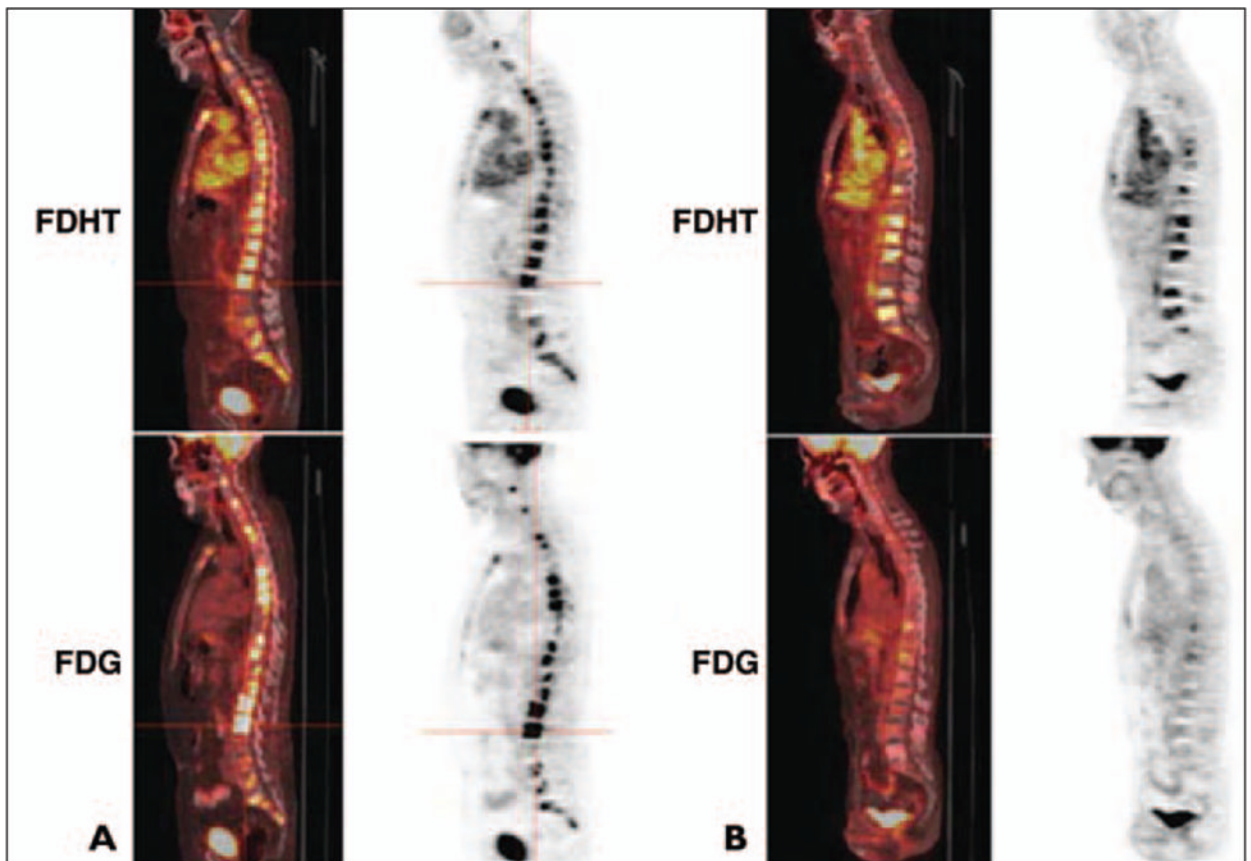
Sagittal fused PET/CT and PET images of $^{16}\beta$ - ^{18}F fluoro-5 α -dihydrotestosterone (FDHT) (*top*) and FDG (*bottom*) uptake in two different patients with castrate-resistant metastatic prostate cancer.
